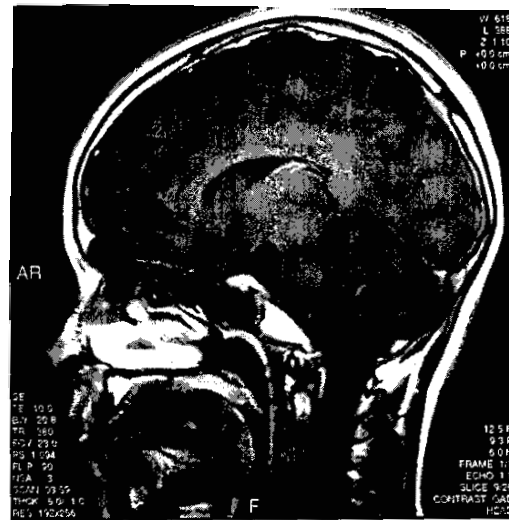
Case 2 at language testing (1 year 10 months post treatment): Sagittal and coronal MRI scans demonstrating no interval change in size or appearance of previously demonstrated astrocytoma in right pons following radiotherapy treatment.
